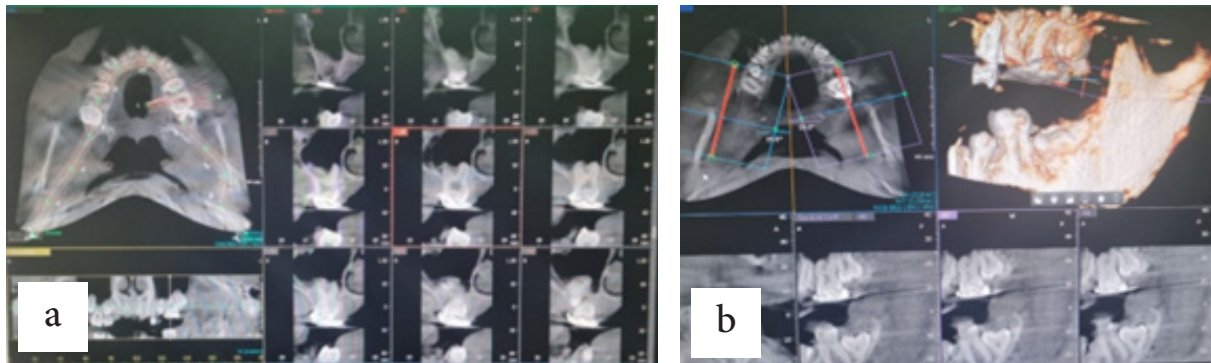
CBCT radiograph of a 12-year-old patient before treatment: a) Occlusal view of upper dental arch and labial view of partial absence of alveolar bone and periodontal ligament of the left-side maxillary and mandibular first molar, b) Notable extrusion of the left mandibular first molar due to absence of antagonist (maxillary first molar) and unilateral mastication.
